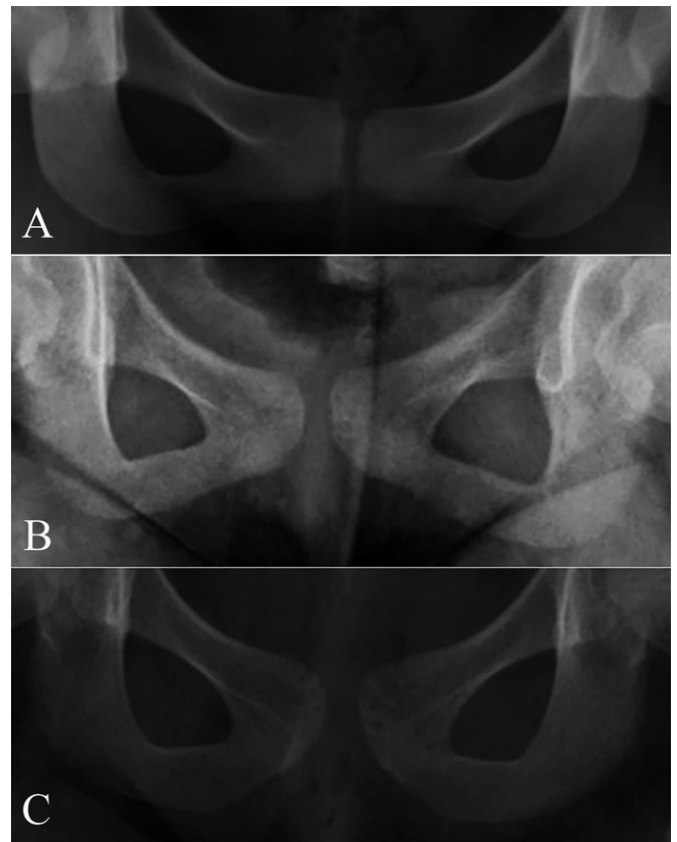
Radiographic examples of subpubic contour scores: A) score 1, concavity; B) score 2, straight; and C) score 3, convexity.
